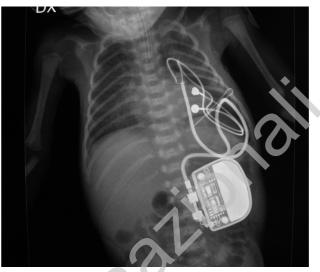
Chest X-ray after implantation of device.
